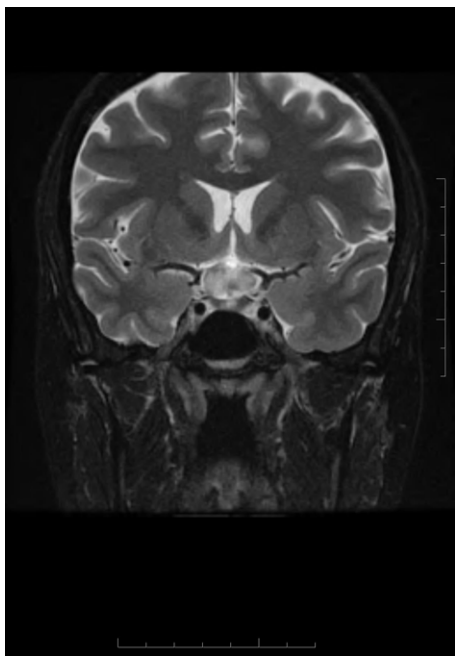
Coronal T2W MRI with gadolinium showing enhancement of the optic chiasm.
